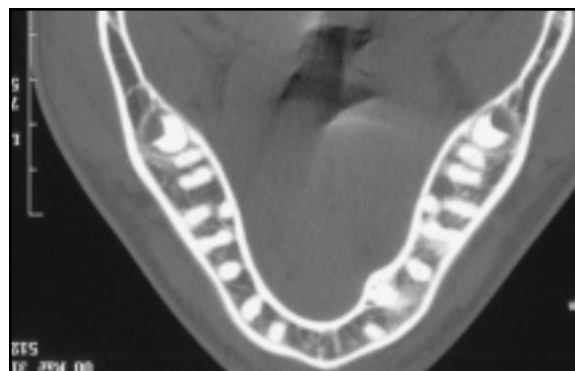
CT section shows space for micro-implant buccal and distal to mandibular second molar.
